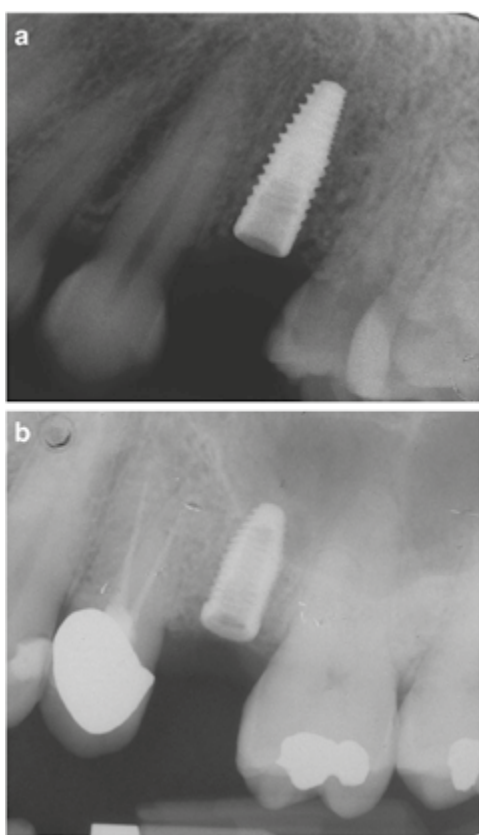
a, b: Postoperative radiographs
